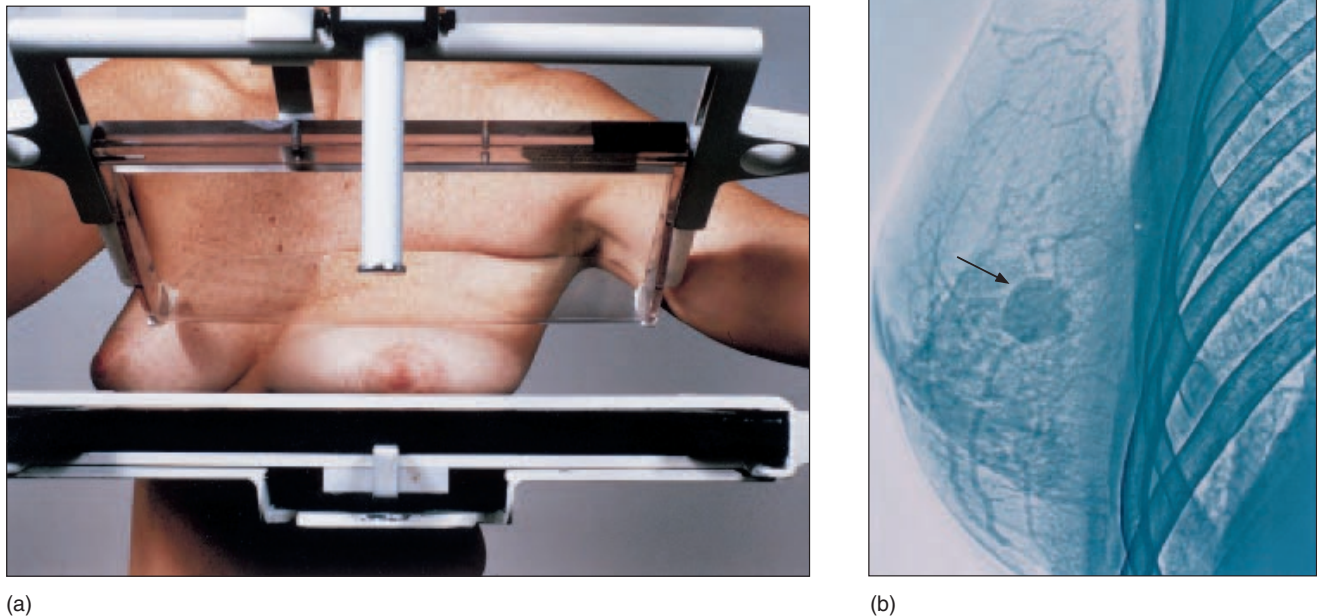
(a) In mammography, the breast is placed alternately on a metal plate and radiographed from above and from the side. (b) A mammogram of a patient with carcinoma of the breast. (Note the presence of a neoplasm indicated with an arrow.)
